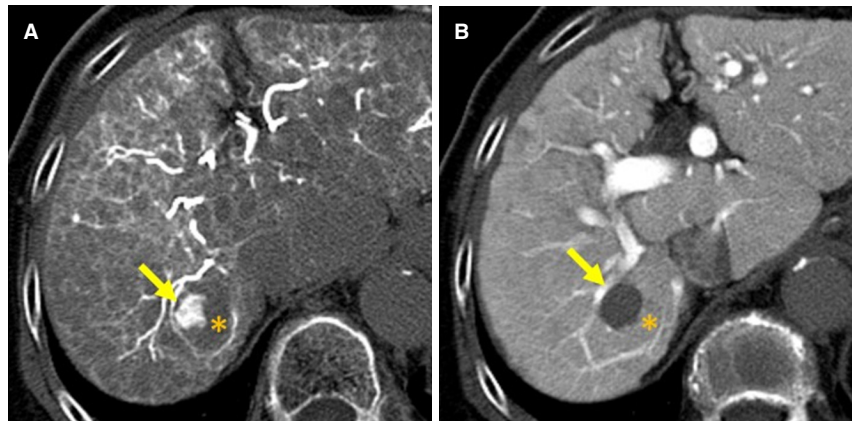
Hypovascular nodule with hypervascular foci (nodule in nodule appearance lesion). A: on CT during hepatic arteriography, hypervascular foci (arrow) is observed within hypovascular nodule (*); B: on CT during arterial portography, only hypervascular portion on CT during hepatic arteriography (arrow) shows hypointensity and other portion of the nodule show isointensity to the background liver (*). In this nodule hypovascular portion of the nodule (*) are relatively benign nature and hypervascular foci represents dedifferentiated more malignant nature
